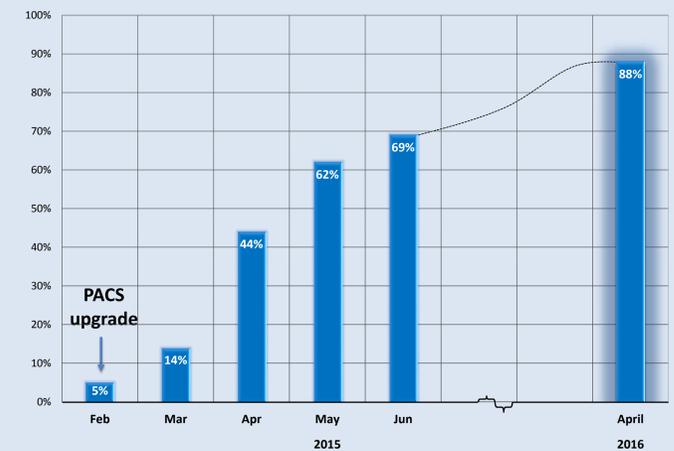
Percentage of hyperlink usage by body CT radiologists at NIH Clinical Center after the incorporation of this capability (PACS upgrade)
